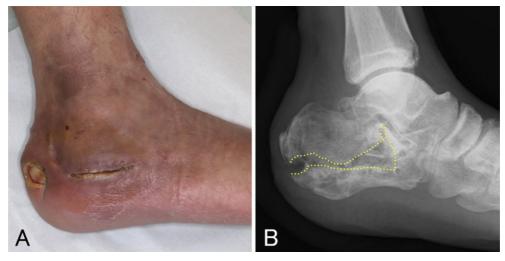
Preoperative clinical (A) and radiographic appearance (B) of the complex calcaneal defect. A yellow dotted line indicated pseudo articulation.
